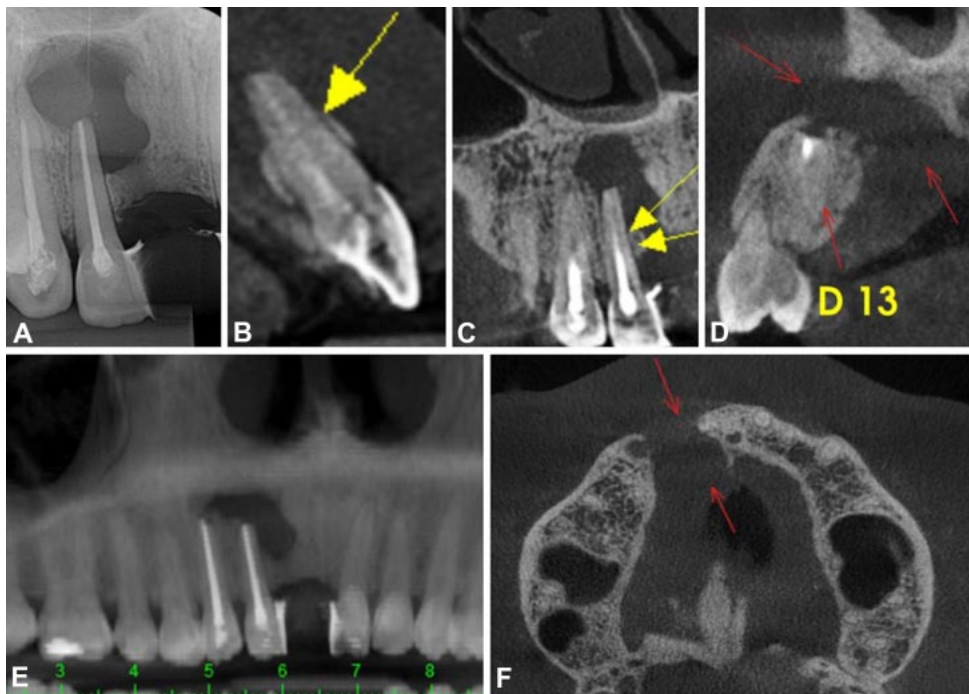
Postoperative control. (A) Periapical radiography two months postoperative. While the tomography at ten months postoperatively revealed an image suggestive of a root fracture or crack in the buccal-mesial face of the root, (B) in the sagittal and (C) coronal sections. (D) Tooth 13 showed a reduction in the height of the bone defect in the sagittal section. (E) A tomographic image of the panoramic section demonstrates reduction of the lesion, and (F) axial section demonstrates the permanence of the vestibular and palatal cortical loss.
